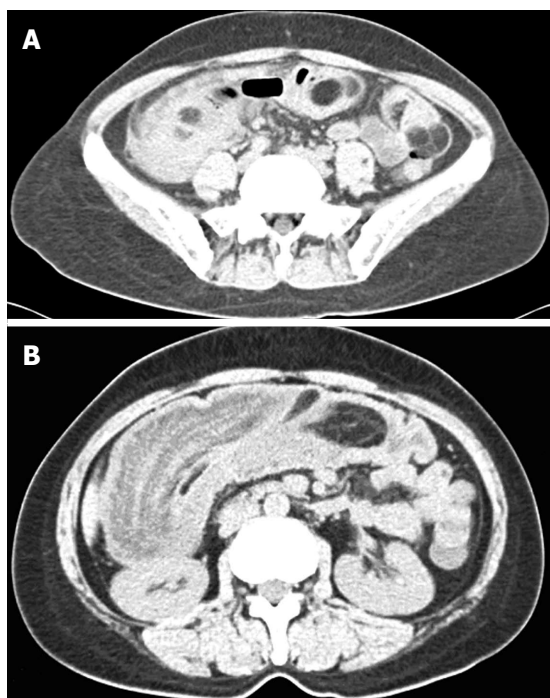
Abdominal computed tomography. A: Abdominal computed tomography (CT) (transverse view) revealed diffuse and multiple intramural fat density masses in the small intestine; B: Abdominal CT showed ileo-colonic intussusception.
